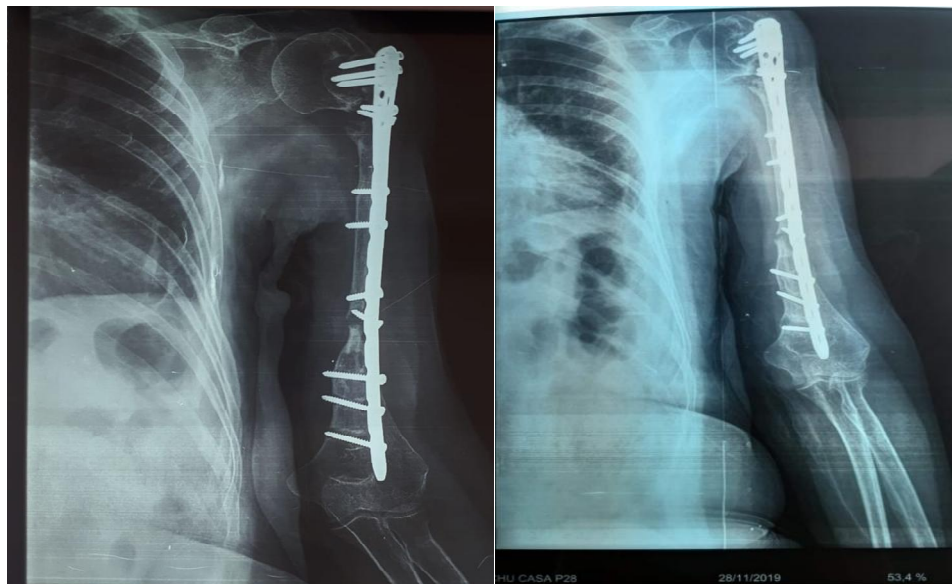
Frontal X-ray after 30 months of follow-up showing the fibular graft well in place with precarious union proximally and distally
